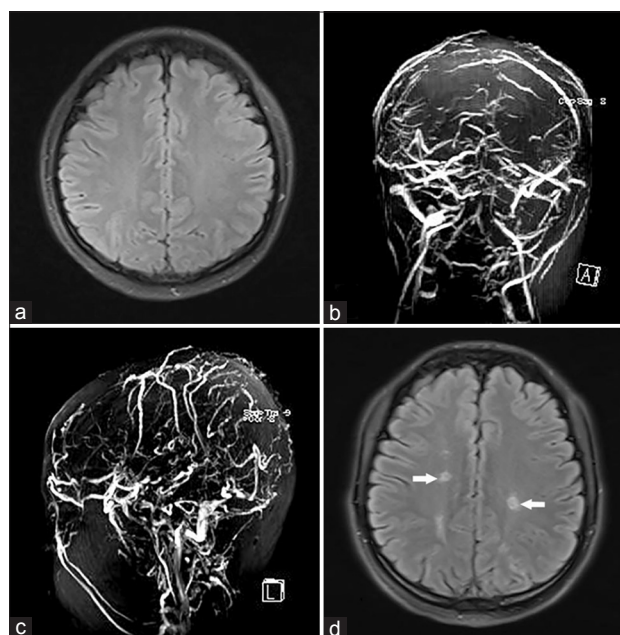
Cerebral venous sinus thrombosis as the first manifestation of *JAK2*^{V617F}-positive essential thrombocythemia (case 1). An axial T2-weighted MR scan of the brain was normal during the first hospital admission (a). MR angiography showed occlusion of superior sagittal sinus, straight sinus, and bilateral transverse sinus with enriched scalp and superficial vein during the first hospital admission (b and c). Multiple lacunar cerebral infarctions (white arrows) were found in axial T2-weighted MR scan during the second hospital admission (d). *JAK2*^{V617F}: Janus kinase 2V617F; MR: Magnetic resonance.
